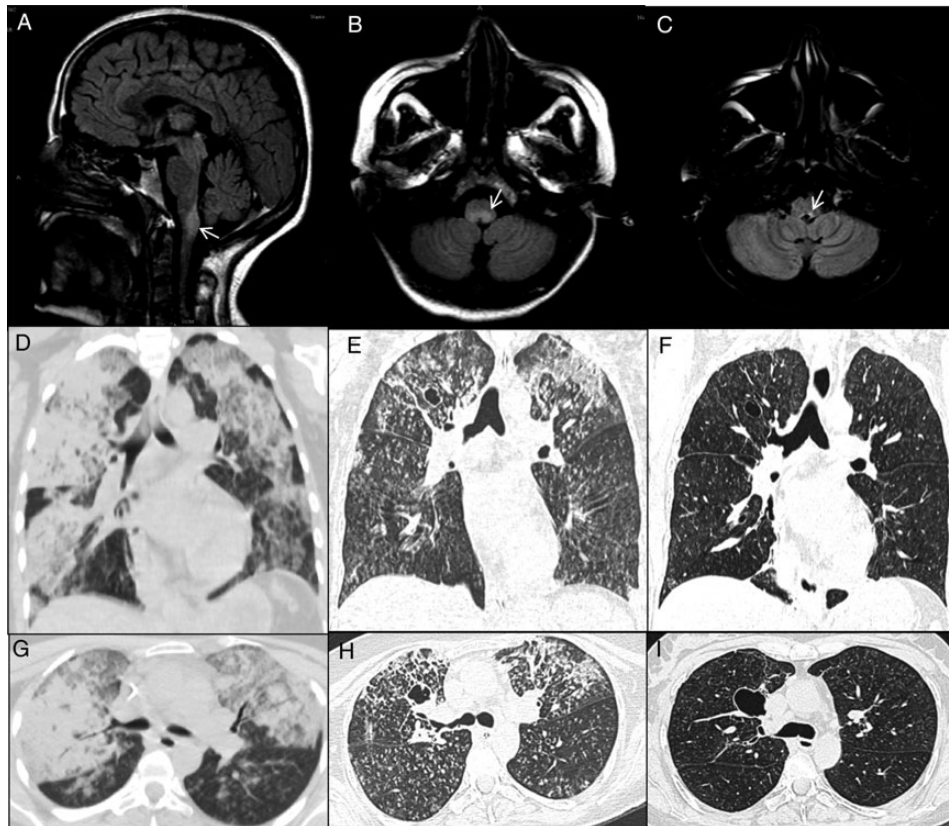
FLAIR brain magnetic resonance imaging shows hyperintense signal (arrows) in dorsal medulla on sagittal (A) and axial (B) views, with regression 10 months later (C). Initial coronal (D) and axial (G) chest computed tomography (CT) revealed multifocal air-space opacification with multiple nodules predominantly in upper lungs bilaterally, greater on the right (D). One month later, coronal (E) and axial (H) chest CT revealed more prominent multifocal small nodular opacities randomly in both lung fields, cavitating cystic lesions in the right upper zone and resolving upper lobe consolidation bilaterally. Five months after initial presentation, coronal (F) and axial (I) lung CT showed marked persistence of small cystic areas in the right upper lung, but nearly complete resolution of the fibrotic lesions and micronodular shadows.
